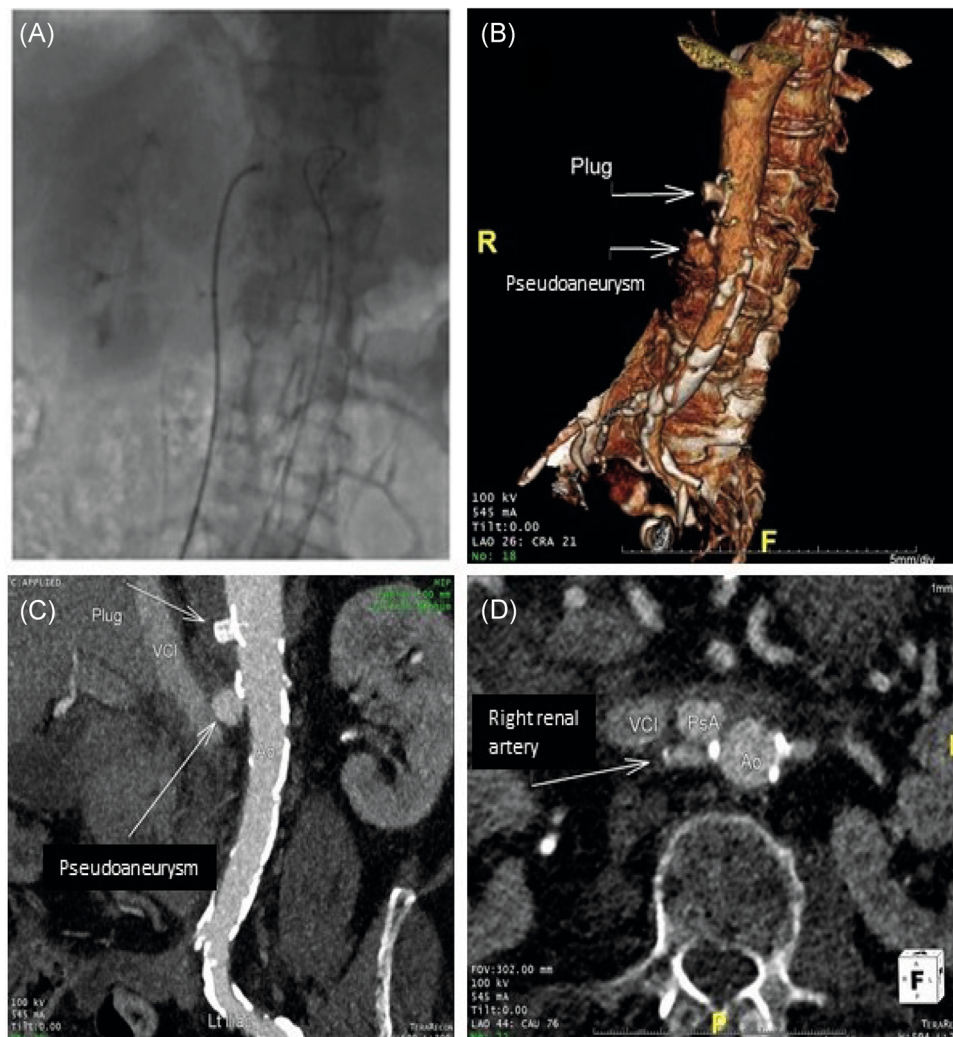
(A) Fluoroscopy during transcaval procedure: crossing the electrified guidewire in inferior vena cava to the aorta; (B and C) Computerized tomography (CT) angiography 3D reconstruction (B) and CT coronal plane demonstrating aortic pseudoaneurysm and the occluder device; (D) CT axial plane demonstrating the relation between aortic pseudoaneurysm and right renal artery [Color figure can be viewed at wileyonlinelibrary.com]
